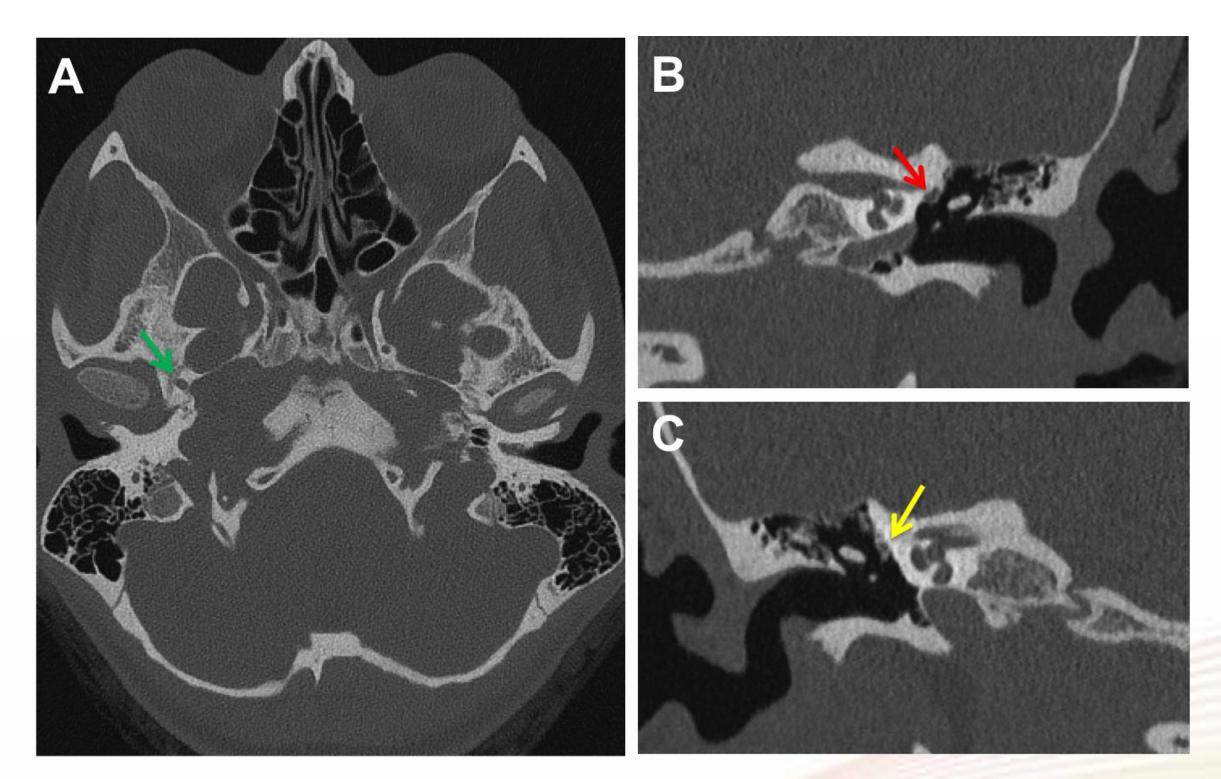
a) Axial CT scan shows a normal right foramen spinosum (green arrow) and absence of the left foramen spinosum. b) Coronal CT scan through left middle ear shows prominent soft tissue at the tympanic segment of the facial nerve likely representing presence of a stapedial artery (red arrow). c) Coronal CT scan through right middle ear shows the tympanic facial nerve is normal in size (yellow arrow). These two findings are diagnostic of an associated persistent stapedial artery. However, there is not enough vascular detail to directly visualize a persistent stapedial artery in this case.
